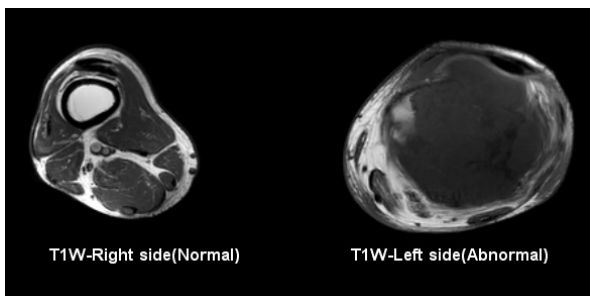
MRI- T1W axial image
